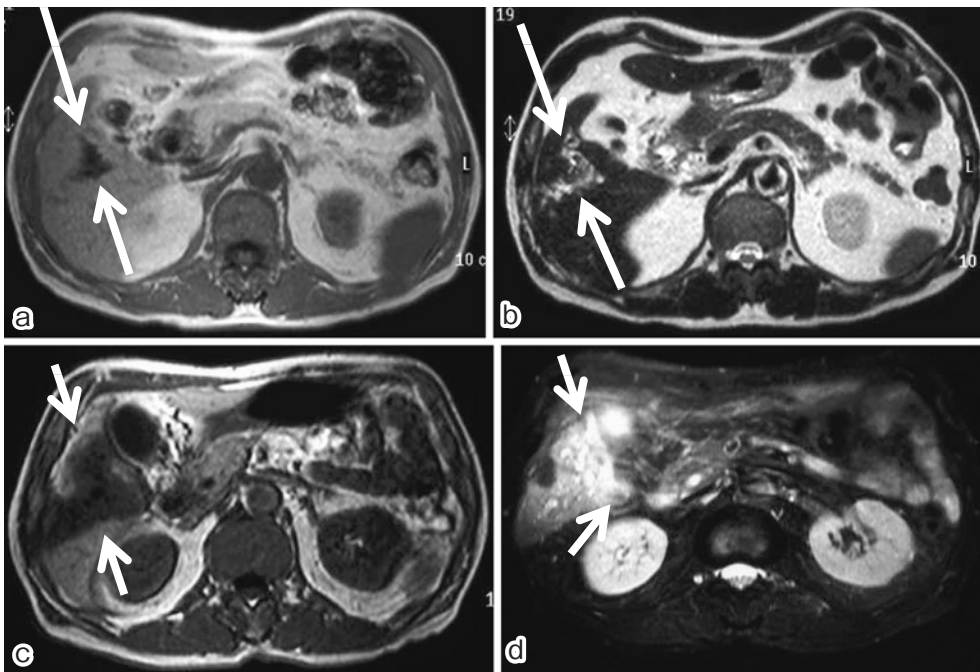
Magnetic resonance imaging showed a lesion of slightly low signal intensity on T1-weighted images (arrows) (a) and a lesion of moderate-to-high signal intensity on T2-weighted images in segment 5 (arrows) (b). Magnetic resonance imaging showed enlargement of this area on T1-weighted images (arrows) (c) and T2-weighted images (arrows) (d).
